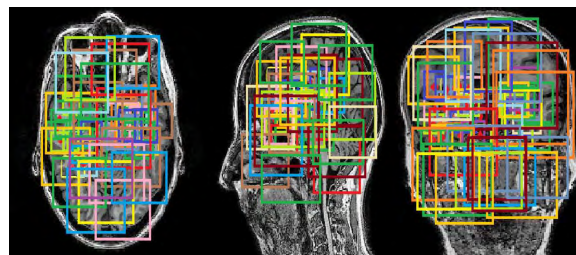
Uniformly distributed random sample points from the whole MRI are used to extract patches except in the boundary region. A 2D representation of a 3D MRI region considered to generate patches for the global model (GH-CNN). Subsequently, 96×96 patches are extracted for the GH-CNN. These patches are downscaled to 32×32 and then merge those 3-plane view 2D patches into 3-channel 32×32 patches.
